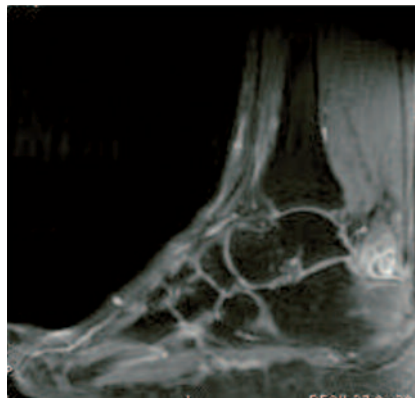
MRI showing Achilles enthesitis. Severe diffuse posterior calcaneal bone oedema extending a long way from the site of attachment of the Achilles tendon is present, as well as retrocalcaneal bursitis and Achilles tendinosis.
